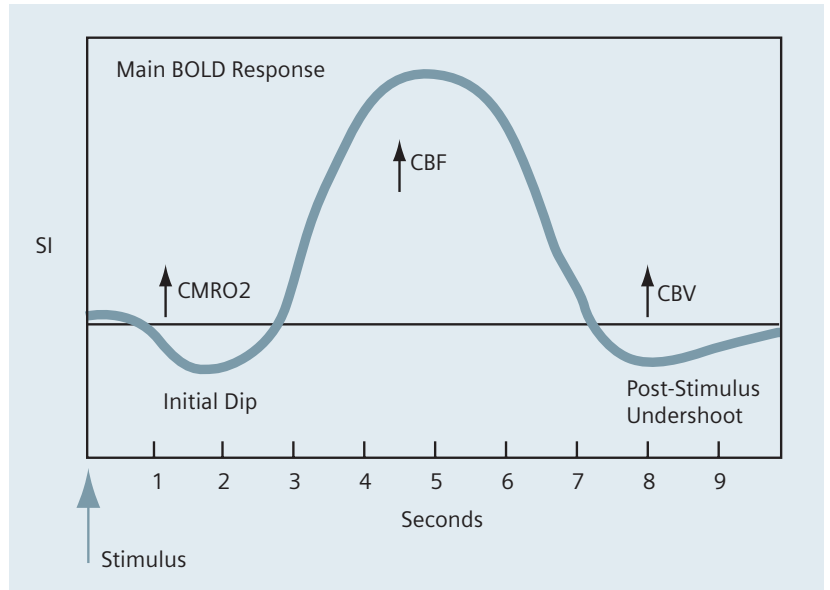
The timecourse of the BOLD response due to a short stimulus is shown with three distinct phases. The most robust signal change occurs approximately 5 seconds after the stimulus and is readily detected by MRI.
